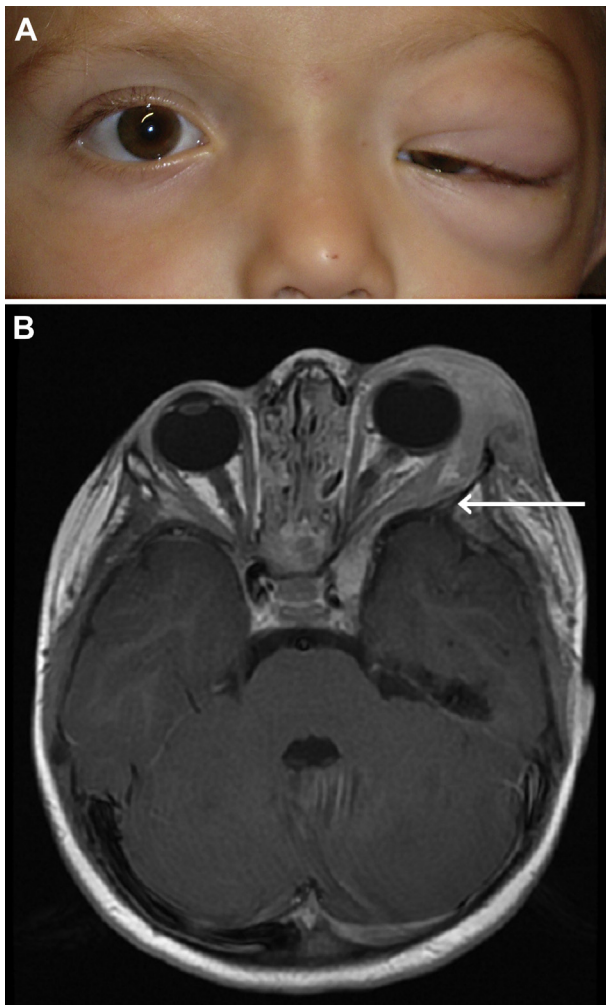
A, Infiltrative orbital-periorbital plexiform neurofibroma (OPPN) resulting in anisometropic and deprivational amblyopia. B, Magnetic resonance imaging (MRI) of infiltrative OPPN and sphenoid wing dysplasia. Arrow indicates the forward protrusion of the anterior temporal lobe and displacement of the orbital contents.
